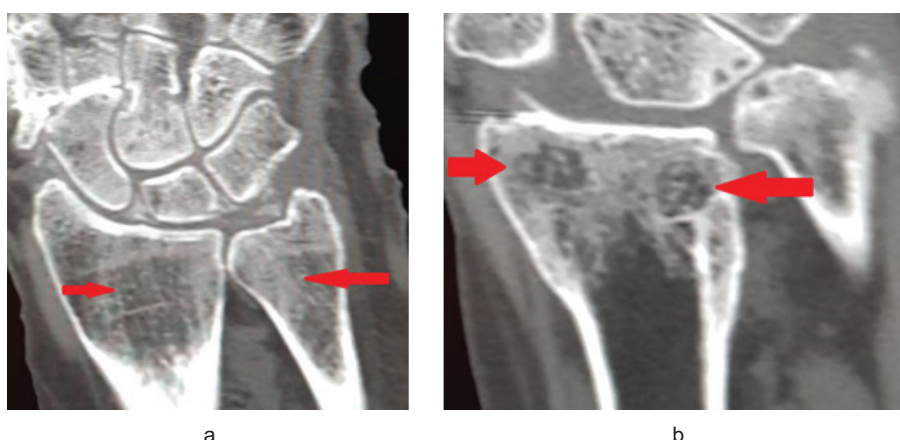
Spiral computed tomography of the wrist joint in persons over 70 years of age, bone-destructive reconstruction of the distal metaepiphysis of the forearm bones, sclerotic changes in the bone matrix trabeculae (a), the formation of "voids" in the form of cystic bone tissue rearrangement (b) - indicated by arrows
